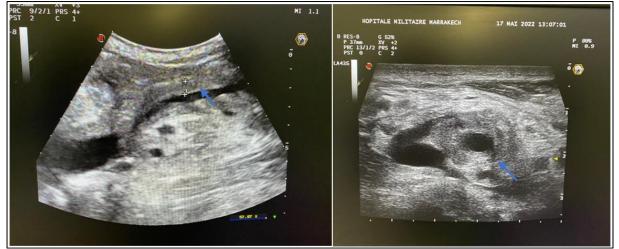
Axial (A) and sagittal (B) ultrasound images showing a hypoechoic a circumferential mass (arrow) surrounding the superior mesenteric artery
